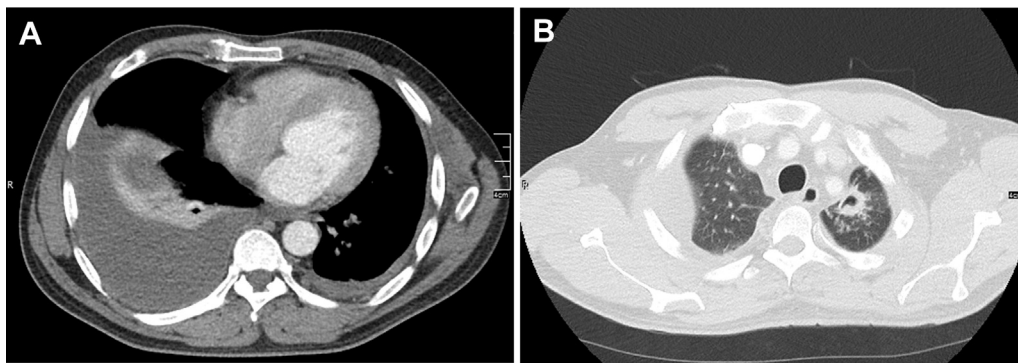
Chest CT scan showing (A) bilateral pleural effusions and (B) a cavitary lesion in the apicoposterior segment of the left upper lobe.
